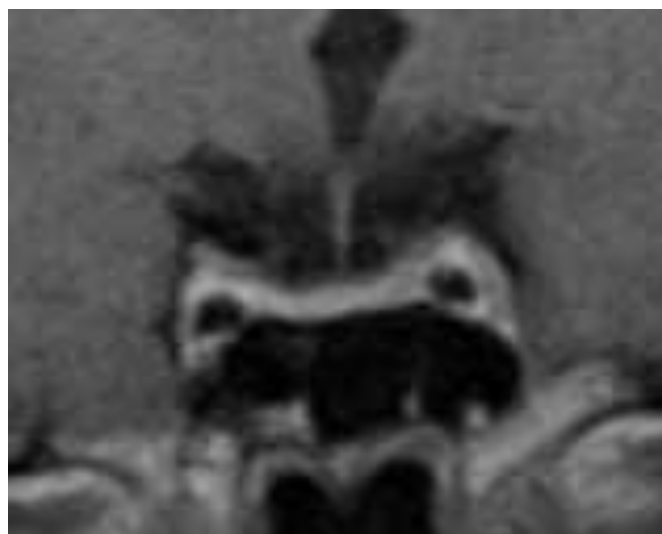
Third postoperative month (follow-up visit), Coronal section of MRI showing complete resection of the pituitary tumour
